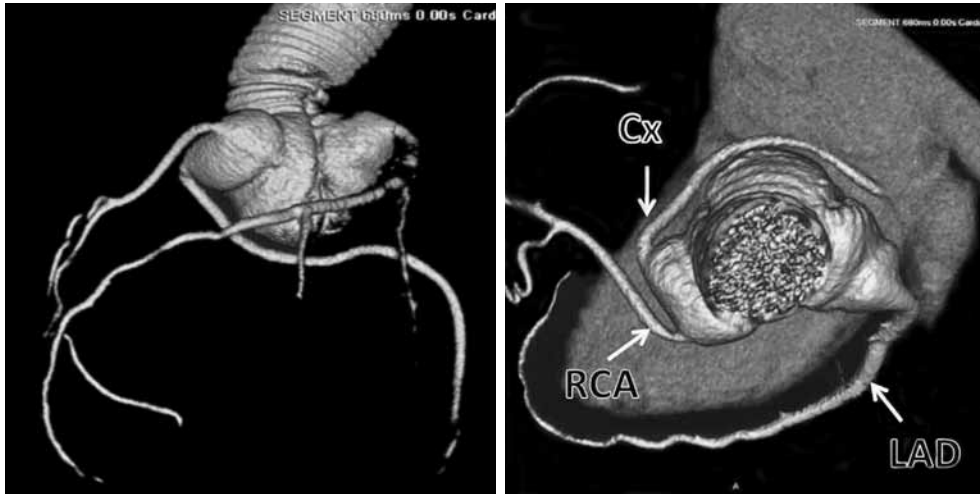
Postoperative one-month three-dimensional computed tomography of the patient showing the intact coronary flow and preserved aortic annulus. The right coronary artery button is visible in the right graft pseudosinus. Cx: Circumflex artery; RCA: Right coronary artery; LAD: Left anterior descending artery.
